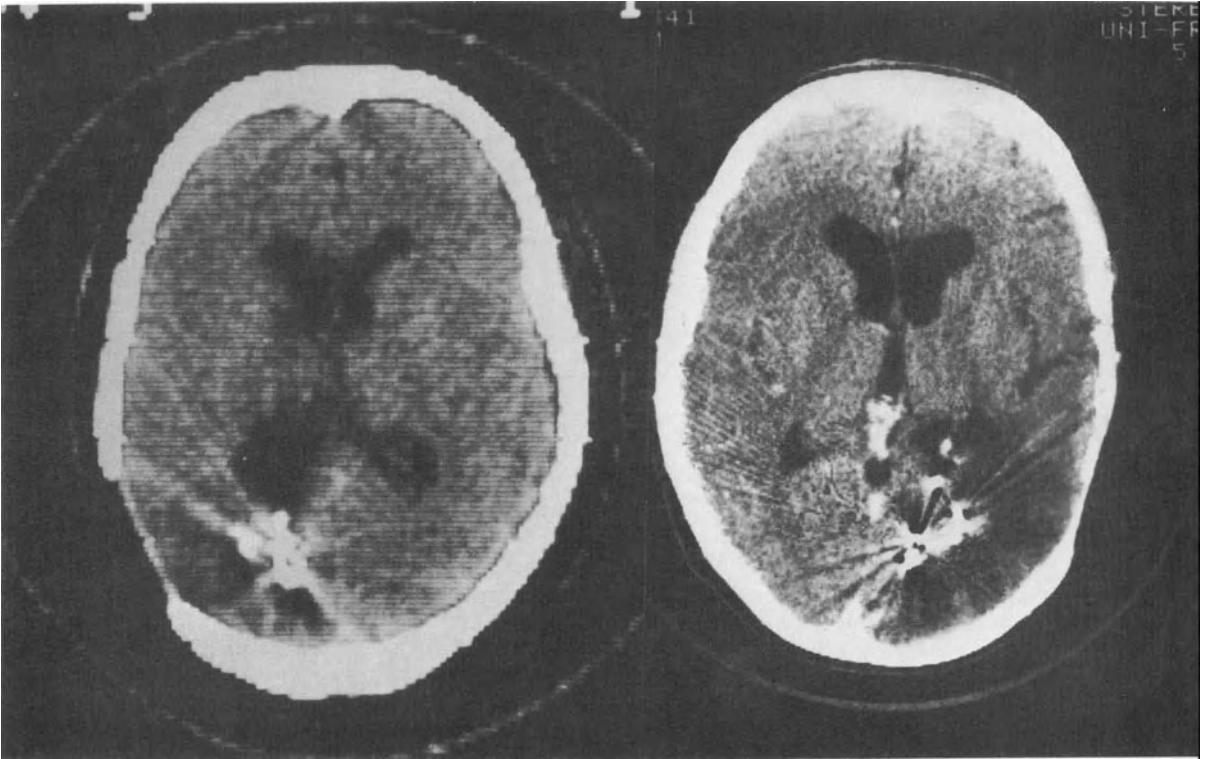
CT scans of a 43-year-old woman with a grade-II protoplasmic astrocytoma. She had open resection of a cystic tumor in 1963 and intraoperative implantation of tantalum-182. A recurrence prompted permanent implantation of ^{192}Ir in November 1978 and insertion of a catheter for possible drainage. (Left) CT image immediately after ^{192}Ir implant. (Right) CT image six years after ^{192}Ir implantation, 21 years following combined operative resection and interstitial Curie therapy. On the left is a parieto-occipital hypodense display of glial changes, presumably a result of irradiation. Occipitally near the posterior horn are numerous metallic artifacts caused by the radioactive implants. The ventricular system is symmetrical; the lateral fissure on the left is somewhat wider than on the right (shrinkage). With the exception of a homonymous hemianopia, the patient has no neurological symptoms. She was since given birth to a healthy child.
